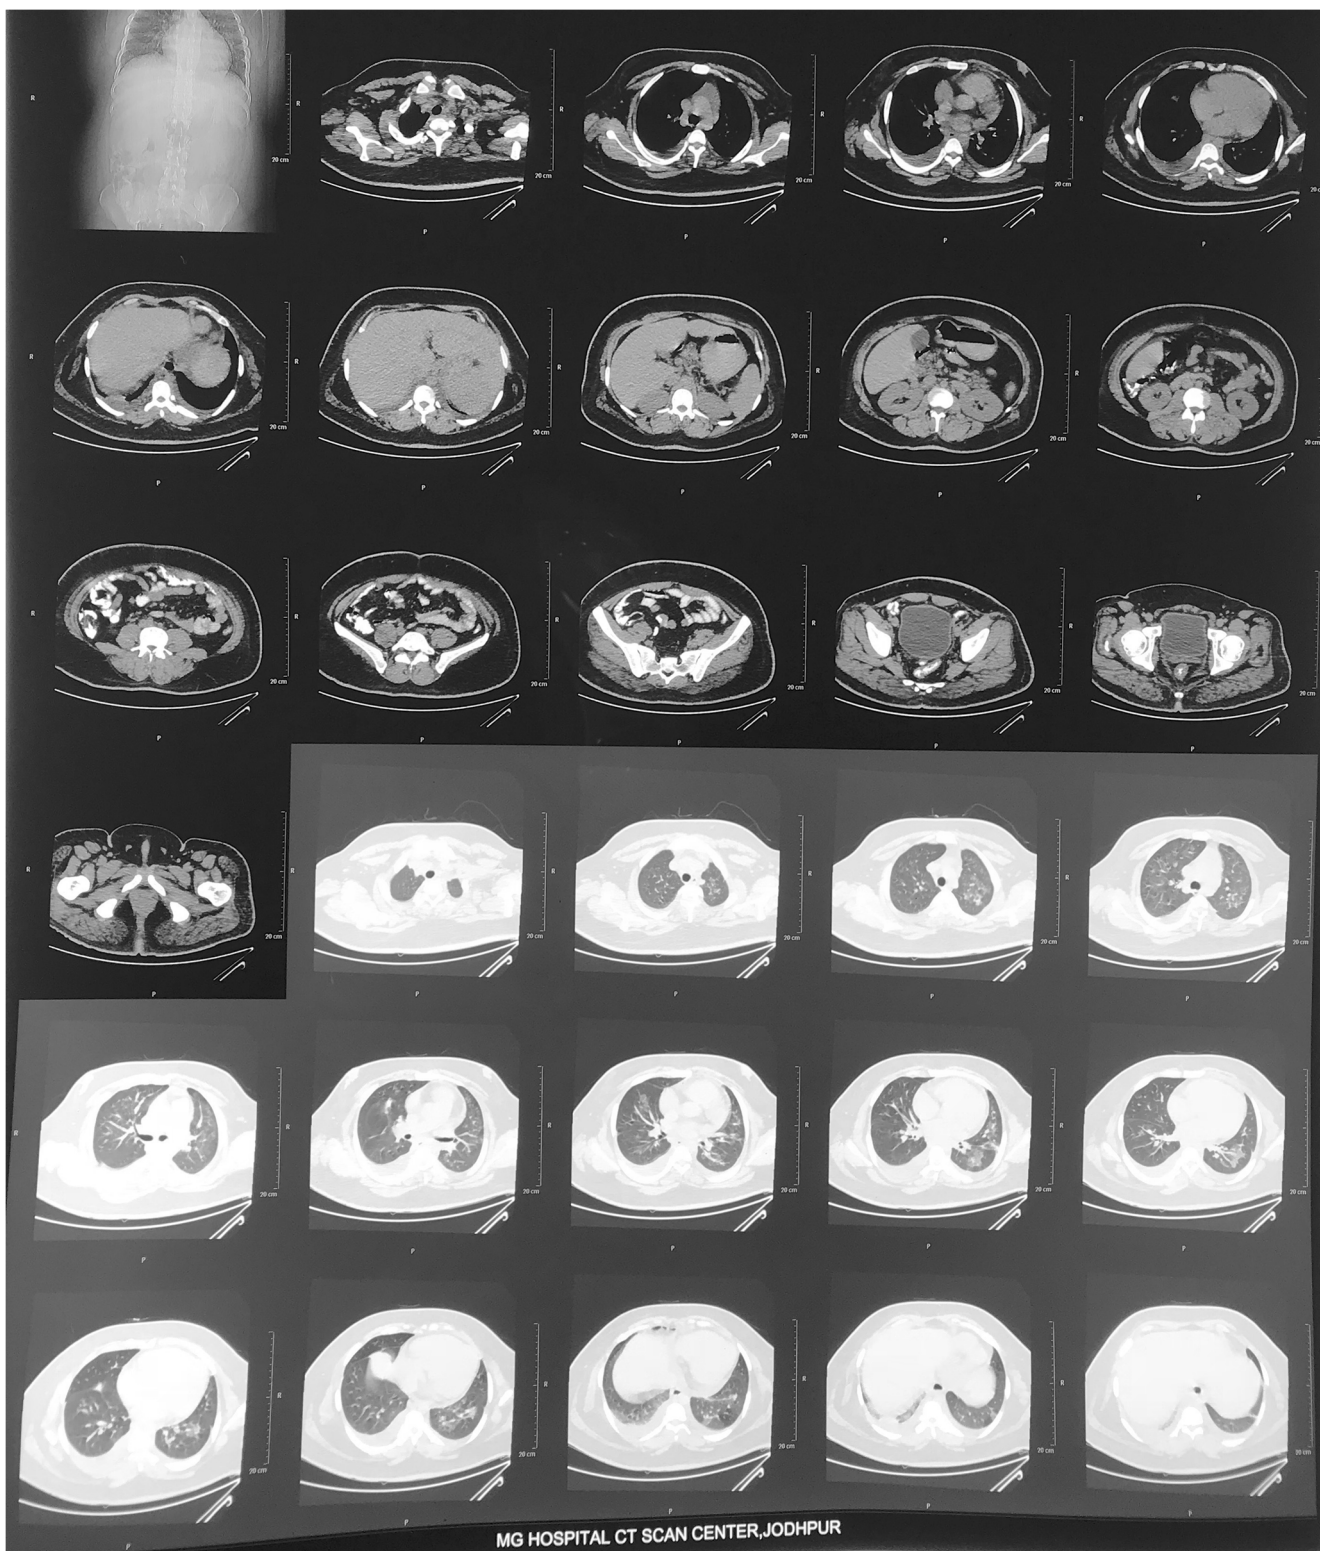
CT of the thorax showing excess fat deposition in chest wall with mild atelectasis of lower lung
